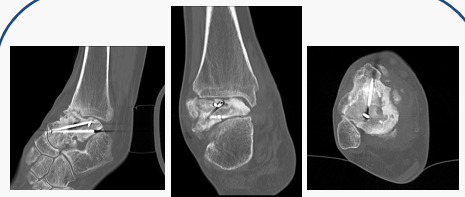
(Above) CT images of talar AVN secondary to trauma
